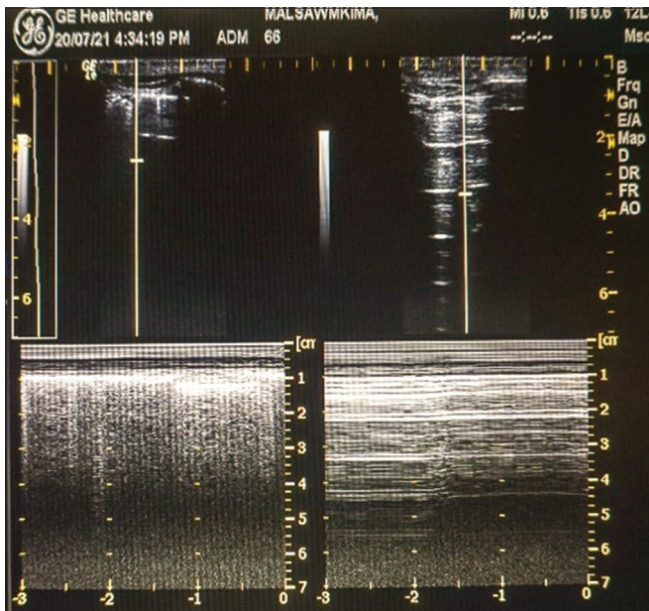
(a) Ultrasound of normal chest showing the seashore sign in Motion mode. (b) The typical barcode or stratosphere sign in pneumothorax which was observed in all our cases in the study
